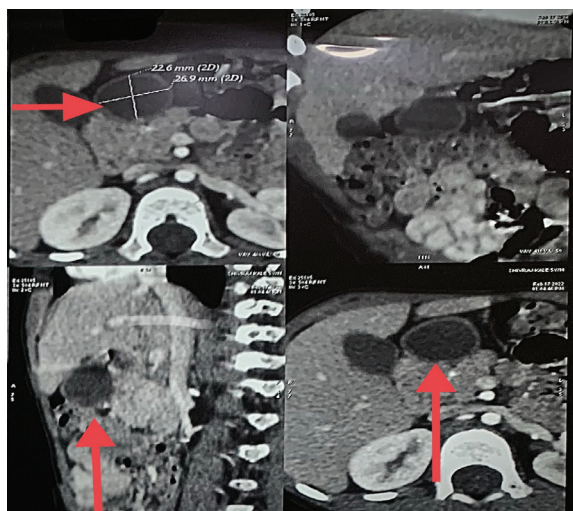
Computed tomography: a hypodense cystic thin-walled lesion (marked with red arrow) of size 27 x 23 mm along the antero-inferior aspect of the pylorus of the stomach.
